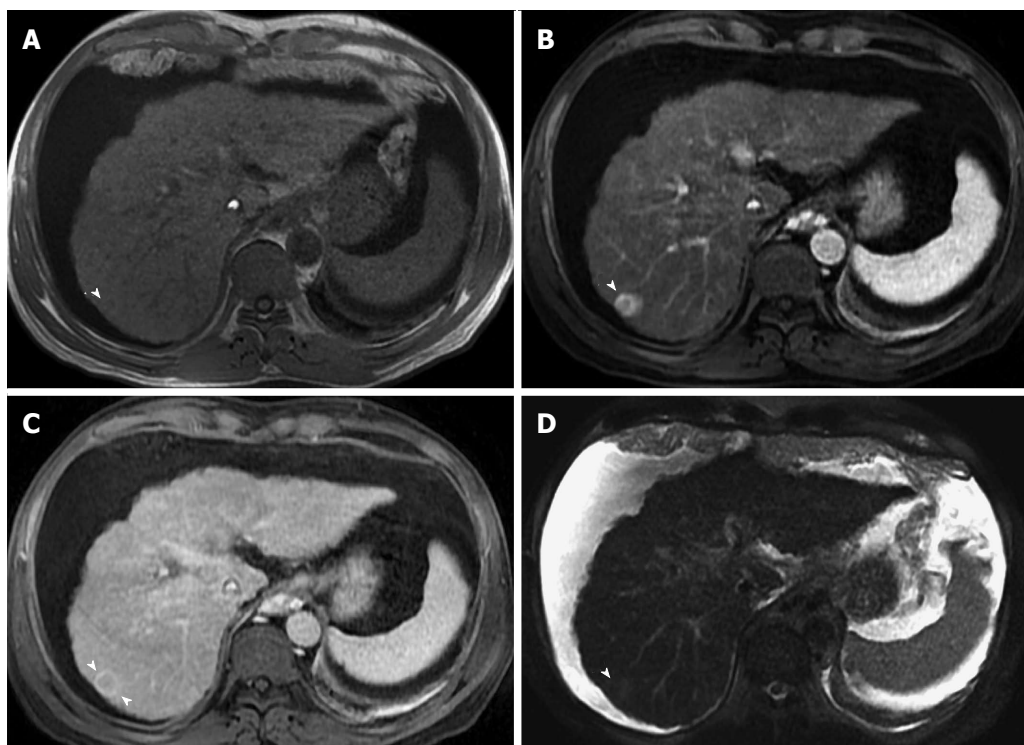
Ring-enhancing hepatocellular carcinoma, indicative of a more aggressive course. A: In-phase GRE T1 weighted image; B: Post-contrast fat-suppressed 3D-GRE T1-weighted images during the (B) late hepatic arterial and (C) delayed phases; (D) Fat-suppressed SSFSE T2-weighted image. There is a small nodule at hepatic segment #7, which demonstrates iso to slightly low T1 signal (arrowhead, A), heterogeneous increased arterial enhancement, predominantly peripheral (arrowhead, B), washout and pseudocapsule enhancement on delayed images (arrowhead, C), and mildly increased T2 signal intensity (arrowhead, D) in keeping with ring-enhancing HCC. HCC: Hepatocellular carcinoma; GRE: Gradient recalled echo; SSFSE: Single-shot fast spin-echo.
